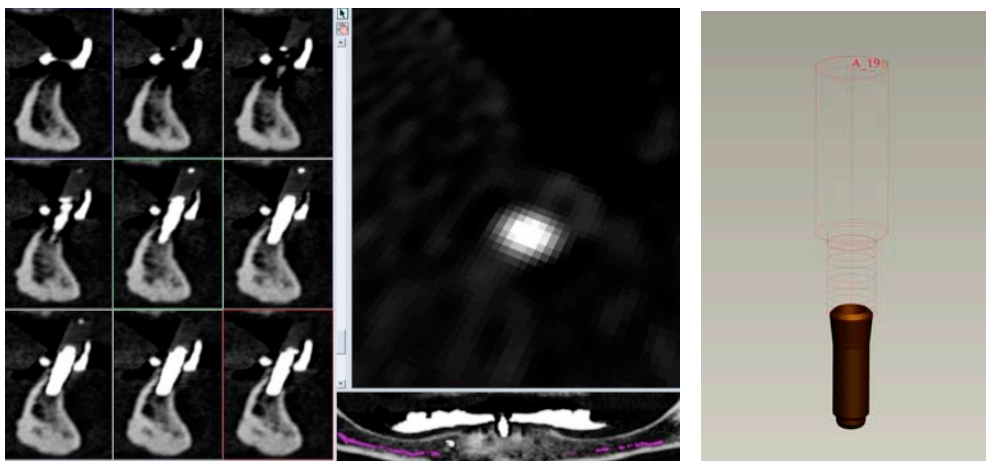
Right, Clearly visible Gutta Percha point on the CT cross-section.
